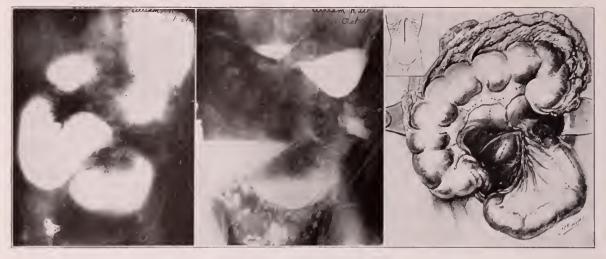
Roentgenographic film of patient showing dilatation of stomach, first, second and third portions of duodenum and first loop of jejunu.n—prone position.
